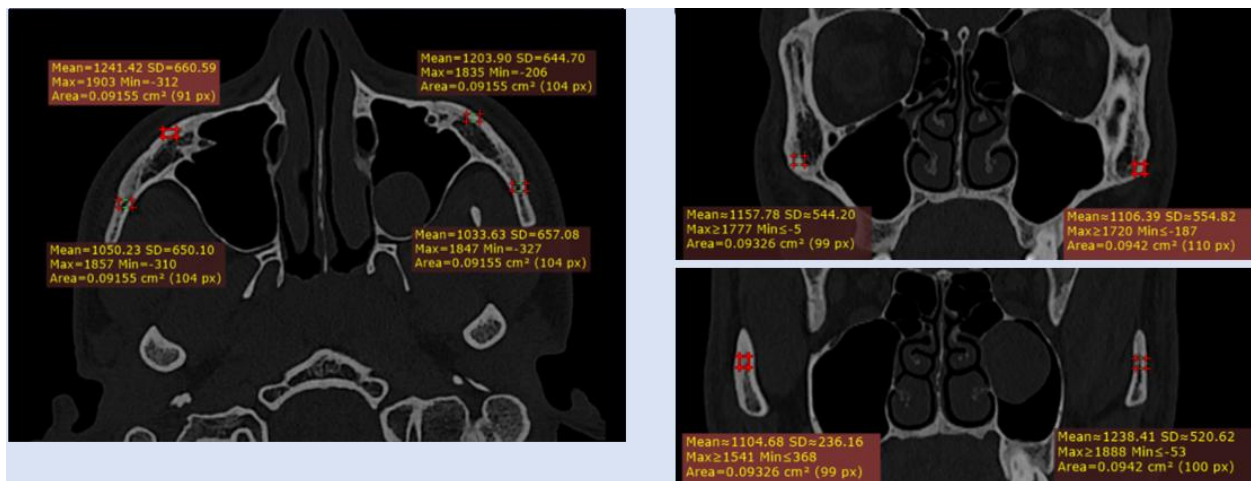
Representative multidetector CT images demonstrating standardized region-of-interest placement for Hounsfield Unit measurements in the zygomatic body and zygomatic arch.
